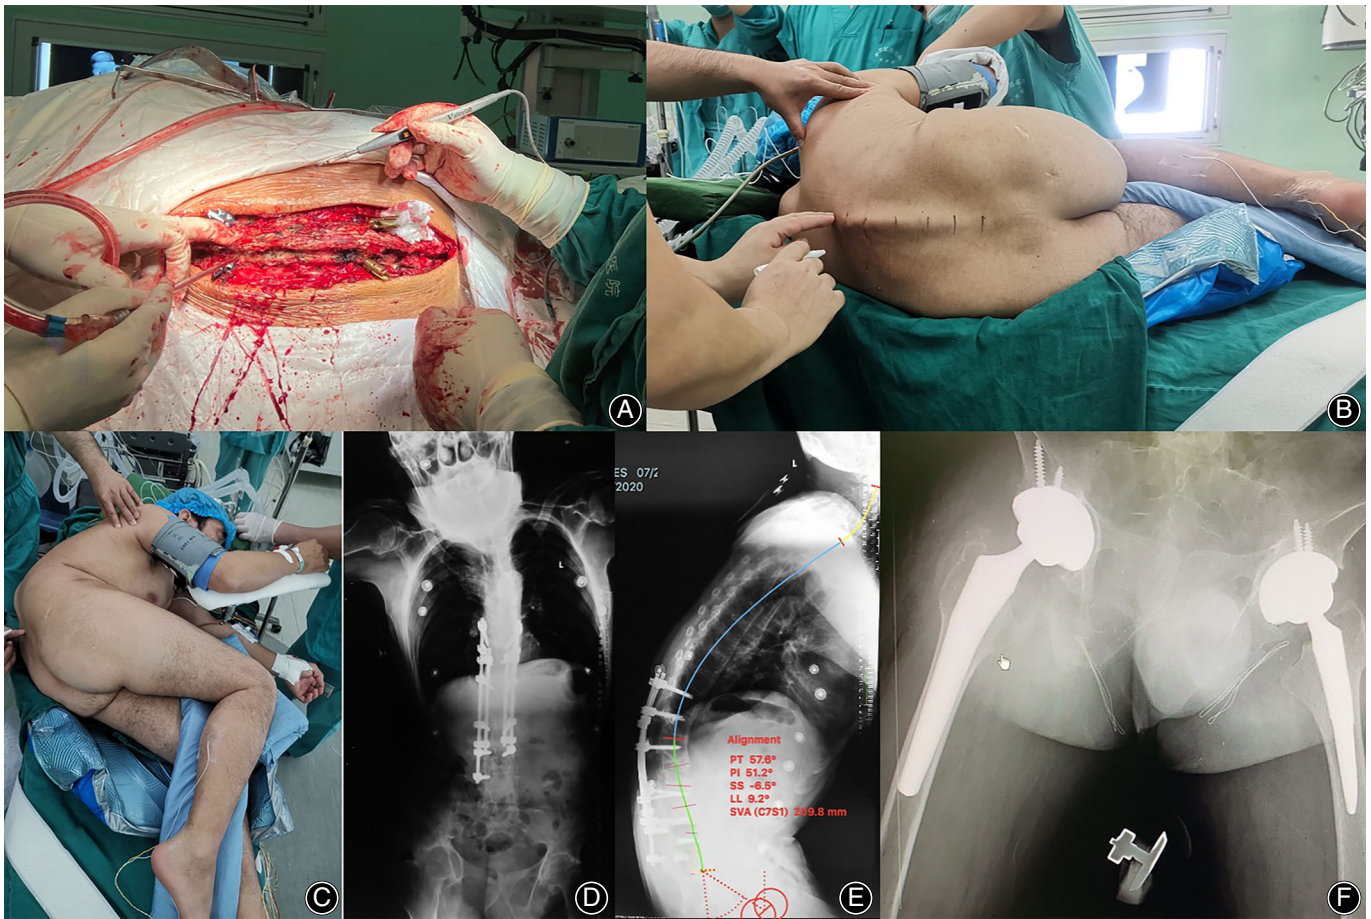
(A) For patient 2, pedicle screws were inserted in a left lateral position. (B, C) Patient 2 was placed in a left lateral position and the operation table was flat. (D, E) Anteroposterior and lateral standing X-ray of patient 2 after PSO at L₂. LL, PT and SVA were 9.2°, 57.6° and 209.8 mm respectively. (F) Anteroposterior X-ray of the patient 2 after THRs.
